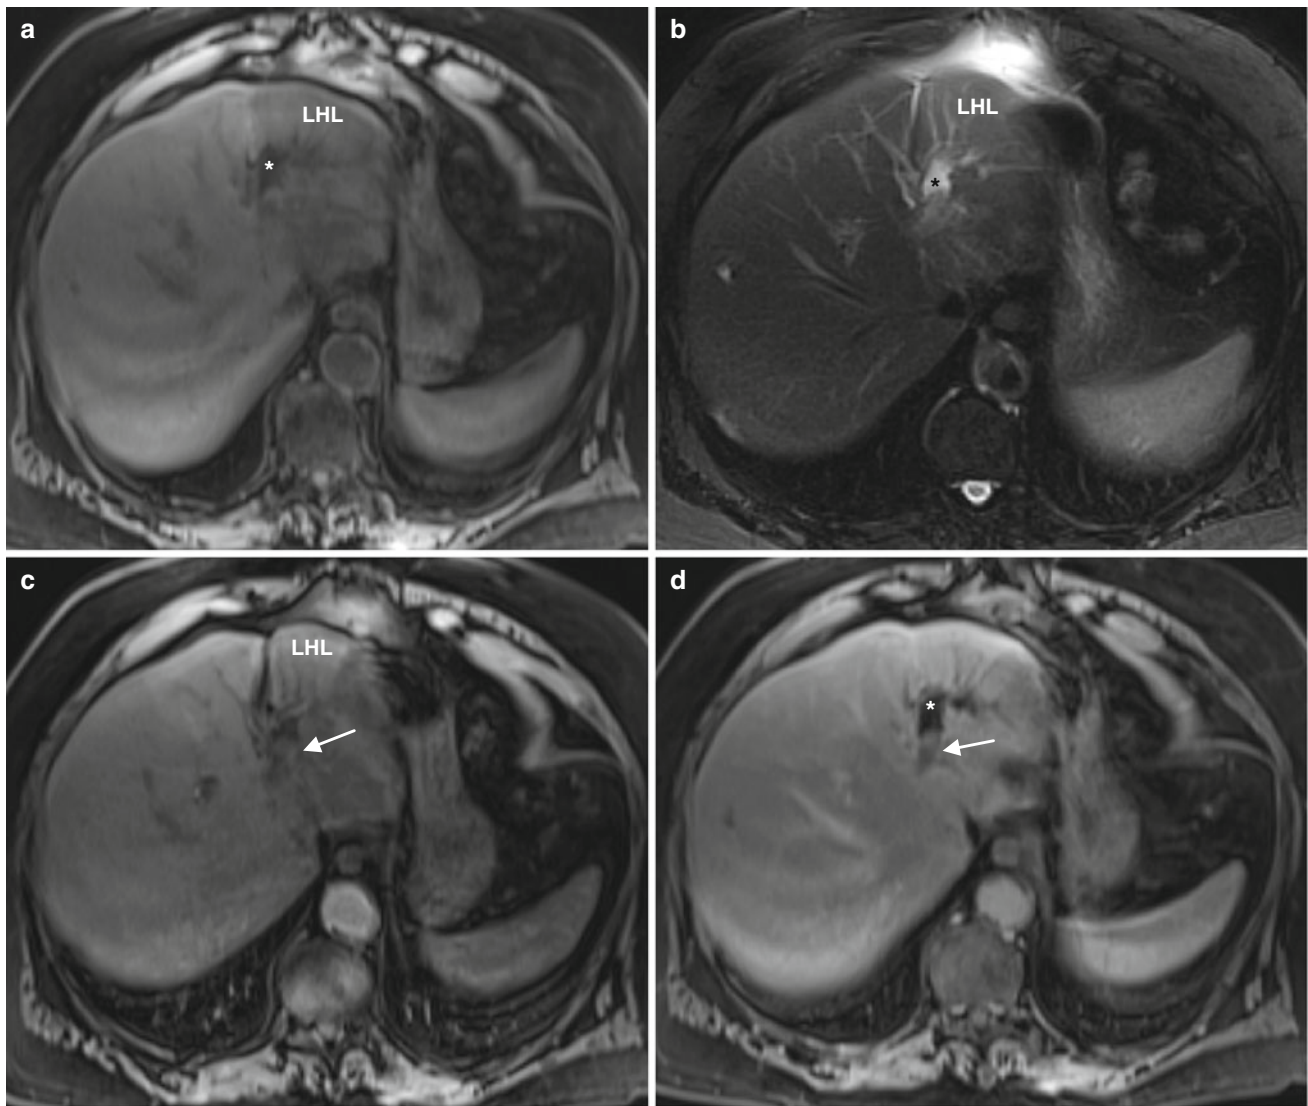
a T1-weighted and b T2-weighted images demonstrate atrophy of the left hepatic lobe (LHL) with intrahepatic biliary dilatation (*). The biliary dilatation terminates at the level of an enhancing mass
